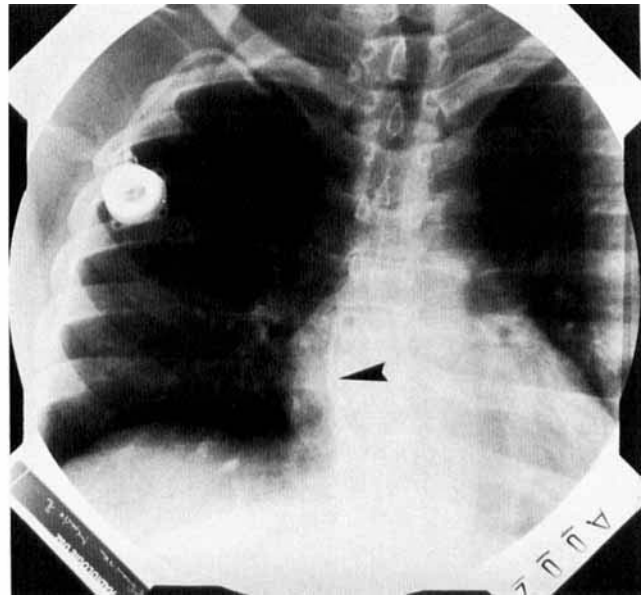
Case report 1. Chest radiograph 3 weeks following catheter insertion, showing a fracture of the silicon catheter with the distal portion in the right atrium (arrow).
